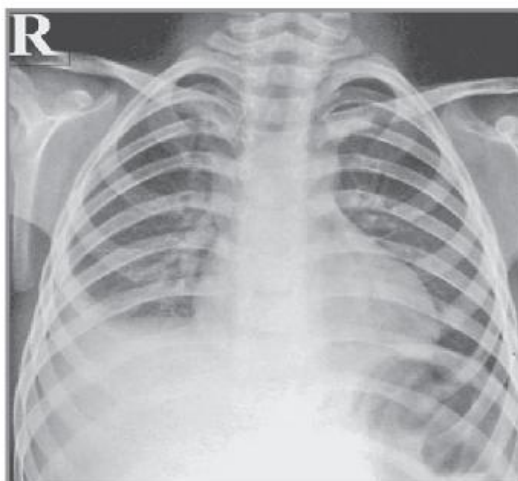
Chest X-ray reveal pleural effusion.
